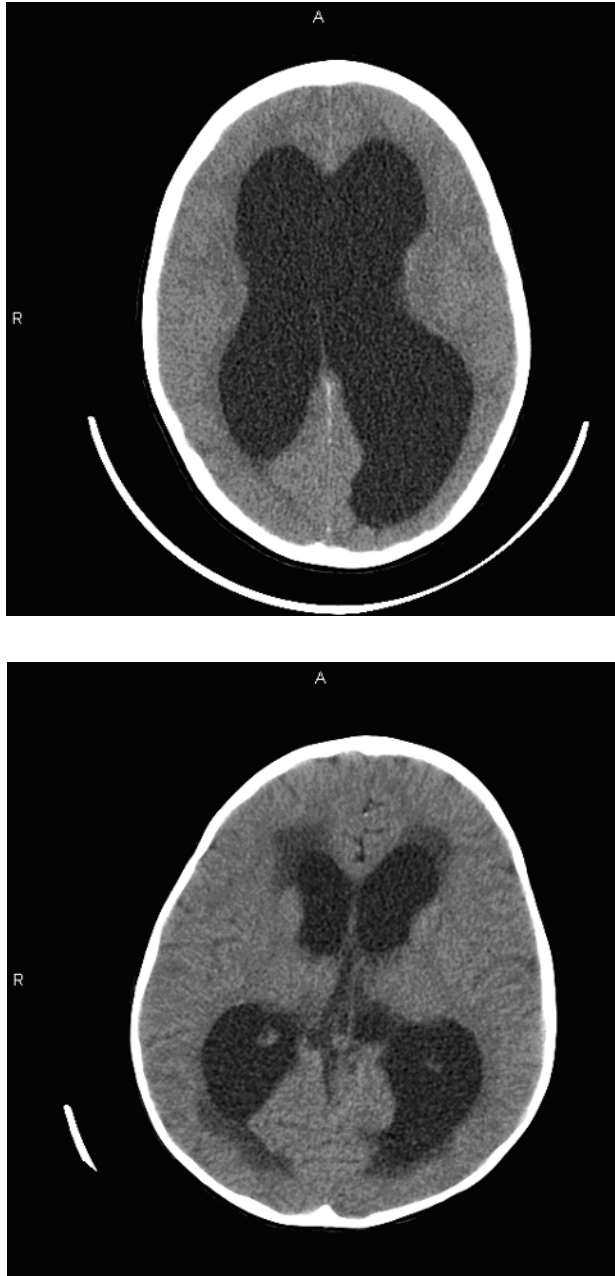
CT scans of a child with hydrocephalus and a child with transependymal flow at the tips of the lateral ventricles. (Courtesy of Jeffrey P. Blount, M.D.)
